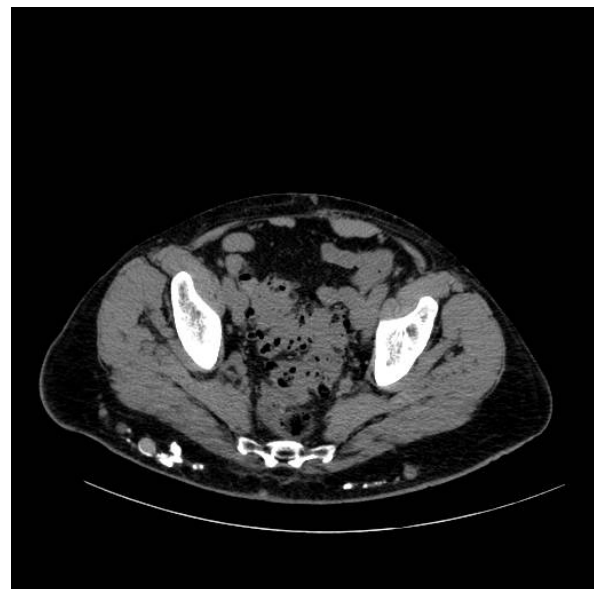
Axial scan of CT of abdomen evidencing well-demarcated lesions on the subcutaneous fat tissue, either fully or rim calcified
